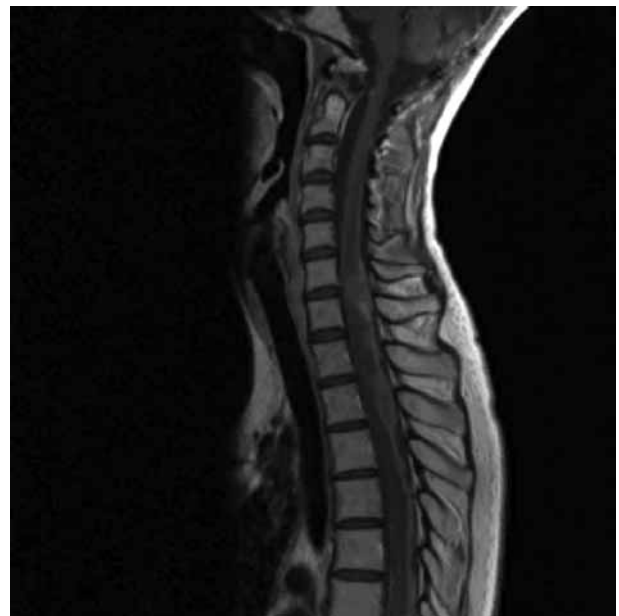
T1 weighted sagittal MRI 7 months after the treatment with temozolomide, still showing no progression.
